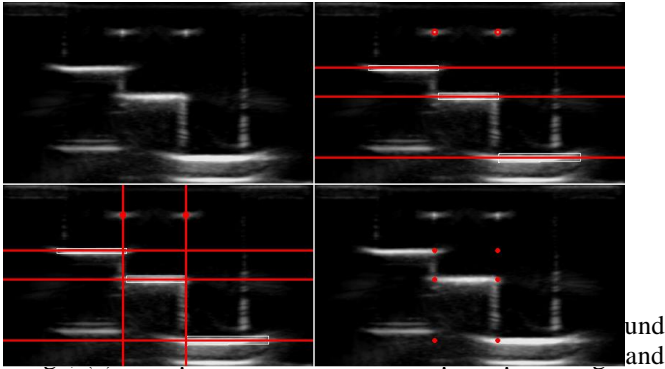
(a) Original ultrasound image; (b) Point part image and three lines are found for the line part image; (c) Two vertical lines are found according to the two points and three lines; (d) Six intersection points are found and two target points can be used for calibration.
